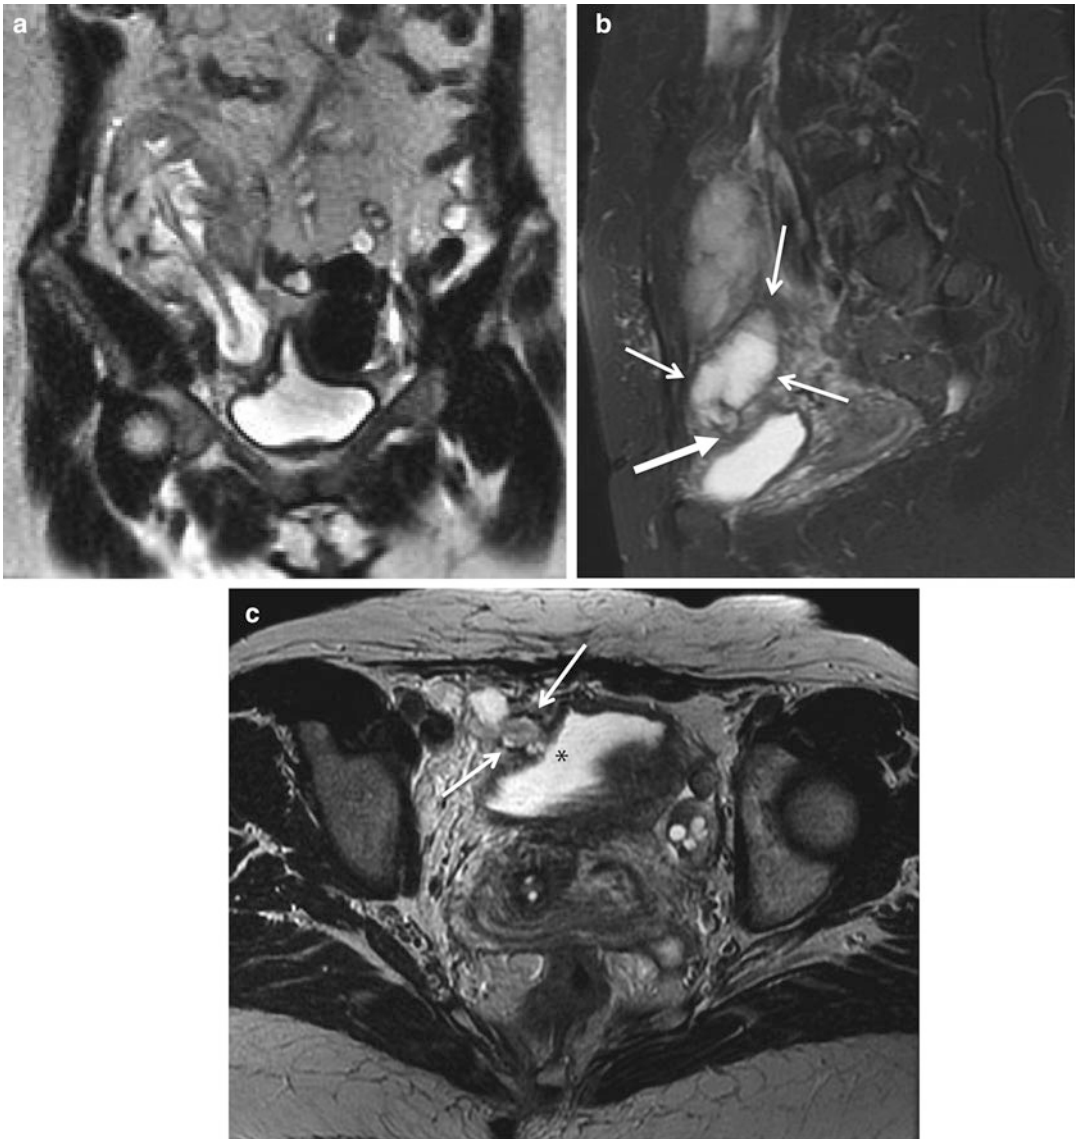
MR urographic imaging demonstrating urinary obstruction. (a) Coronal T2-weighted image shows hydronephroureter involving the renal allograft in the right iliac fossa with a nephroureteral stent in place. (b) The sagittal T2-weighted, fat-suppressed image shows a
